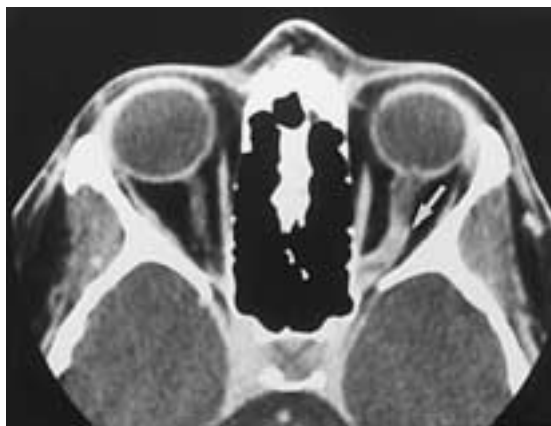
Optic neuritis. Enhanced axial CT scan shows enhancement of the left optic nerve (*arrow*). This may not be differentiated from sarcoidosis or meningioma.
